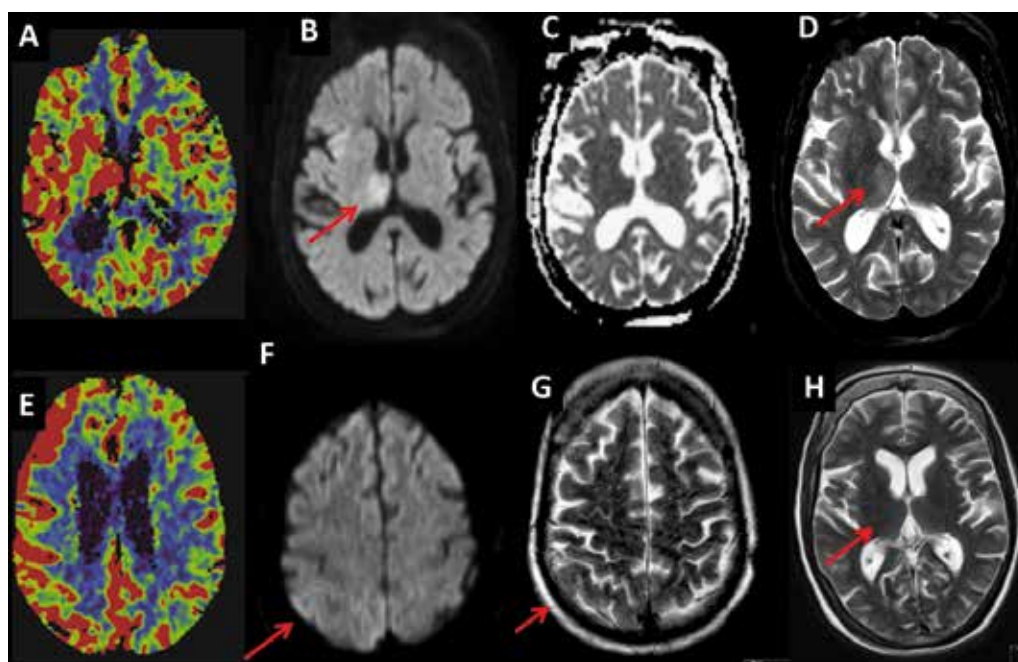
59 year old female with structural epilepsy, during drug withdrawal occurrence of a complex focal SE with clonic movements of left face, shoulder and proximal arm and psychomotor slowing. A-G MRI at 4 days of ongoing focal SE under multiple antiepileptic drugs, A- Hyperperfusion of the right hemisphere including right basal ganglia and right thalamus, B/C- DWI hyperintensity right thalamus; ADC isointens to the contralateral hemispheres representing a mixed cytotoxic and vasogenic edema, D- T2w hyperintensity of the right thalamus (vasogenic edema), E- Hyperperfusion of the right hemisphere fronto-parieto-occipital, F- DWI hyperintensity of the right parieto-occipital cortex, ADC isointensity representing a mixed cytotoxic and vasogenic edema, G- T2w hyperintensity of the right parieto-occipital cortex (vasogenic edema), H- 2 weeks after successful treatment of focal SE – T2w isointensity of thalamic tissue representing (at least in part) reversible structural changes.
